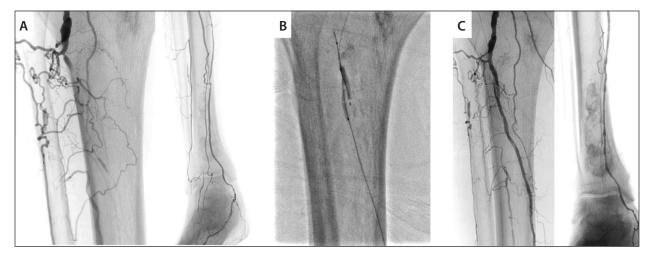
Controlled antegrade and retrograde subintimal tracking for a posterior tibial (PT) and TPT chronic total occlusion. A frail man in his early 70s with diabetes presented with an infected first toe (toe pressure, 20 mm Hg). Delayed DSA demonstrated a PT artery occlusion with reconstitution in the middle third of the calf and a diseased segment patent to the foot (A). Antegrade recanalization was not possible due to the extensive collateral network. The PT artery was accessed at the ankle with ultrasound guidance, and the lesion was crossed in a subintimal plane. Using the CART technique, the subintimal flap was disrupted with balloon angioplasty simultaneously in the distal popliteal artery and TPT (2.5-mm balloon, retrograde) and PT (2-mm balloon, antegrade) artery (B). The true lumen was selected, and from the antegrade approach, angioplasty of the PT artery was performed proximally with a 3-mm balloon and throughout with a 2.5-mm plain balloon. The final angiogram showed good radiographic result with inline flow to the foot (C). The patient's toe amputation successfully healed.
